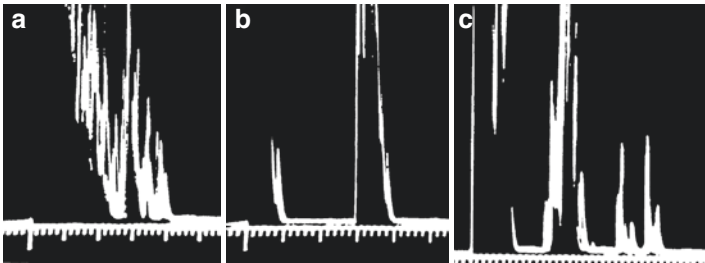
A-mode ultrasound images. (a) An A-mode ultrasound image of a solid thyroid nodule. Scattered echoes are present from throughout the nodule. (b) The image from a cystic nodule. The initial reflection is from the proximal wall of the cyst, with no significant signal reflected by the cyst fluid. The second reflection originates from the posterior wall. (c) The A-mode image from a complex nodule with solid and cystic components
